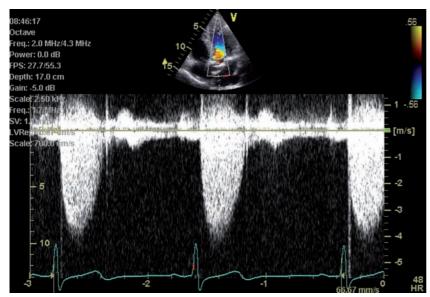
Continuous wave Doppler echocardiogram in patient with severe aortic stenosis (same patient as in figure 2). Transthoracic, two dimensional, apical, five chamber view (inset). A continuous wave Doppler records the maximal velocity across the narrowest point of the stenotic aortic valve and the spectral display is shown. The ratio of the velocity of the blood flow in the left ventricular outflow tract (1 m/s) to the aortic jet velocity (4.5 m/s) is (0.25), which is consistent with severe aortic stenosis
